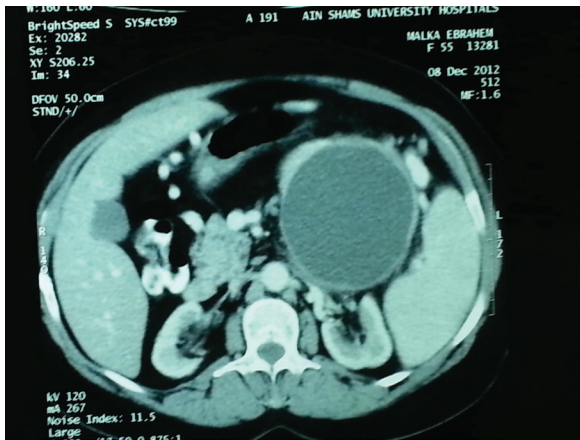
Pelvi-abdominal CT showing large (12 cm) pseudo-pancreatic cyst.
